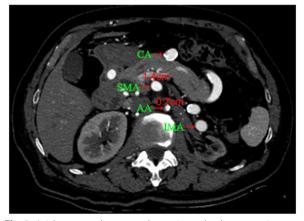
Axial computed tomography angiography demonstrating near-occlusion of the abdominal aorta (arrow) and compensatory visceral artery dilatation
